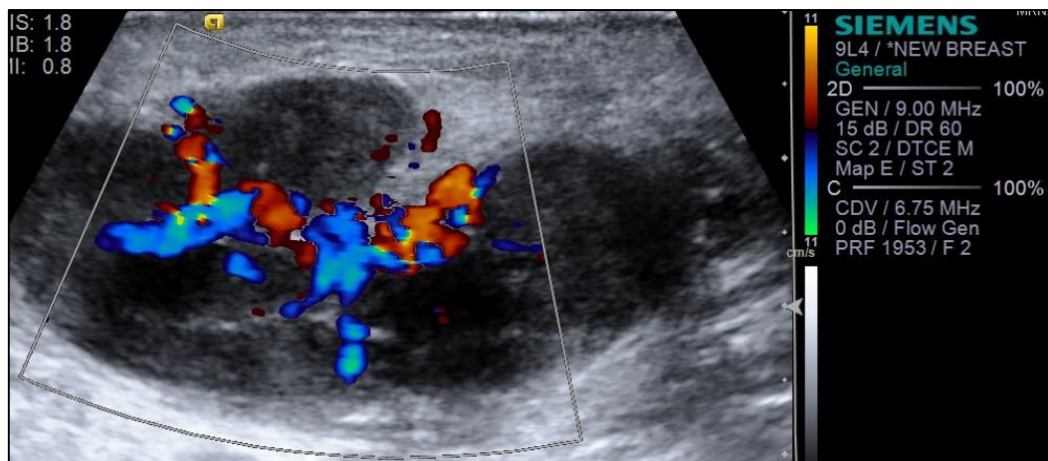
Colour Doppler image of a metastatic lymph node demonstrating increased vascularity
